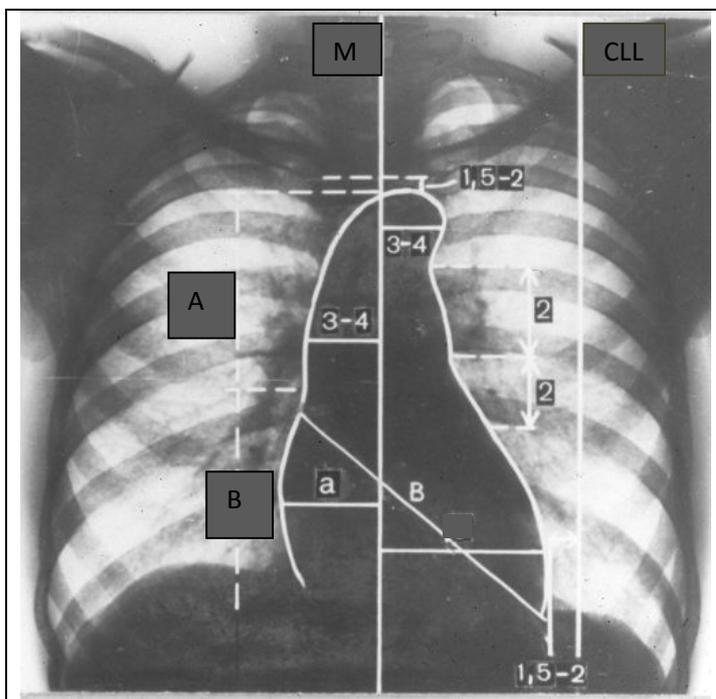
The chart of radiograph of a chest. The sizes of heart arches are specified. M is the median line. CL is the half-clavicular line. A is ascending aorta. B is right auricle.
